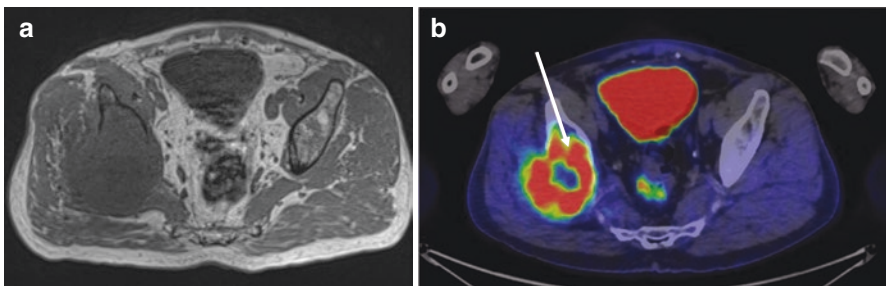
(a) MR image demonstrating large periacetabular osteosarcoma. Biopsy through the buttock will potentially endanger the gluteal flap. (b) PET scan demonstrating hypermetabolic lesion with central necrosis. Arrow indicates that a CT-guided transosseous biopsy through the anterior inferior iliac spine will be able to target metabolically active tissue; avoid the area of central necrosis and remain in line with a standard ilio-femoral incision
